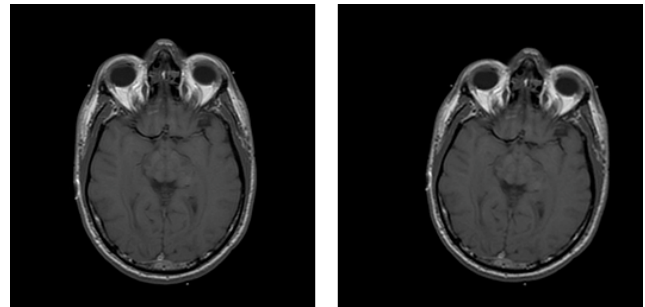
Left: T1-weighted MRI cranial slice
